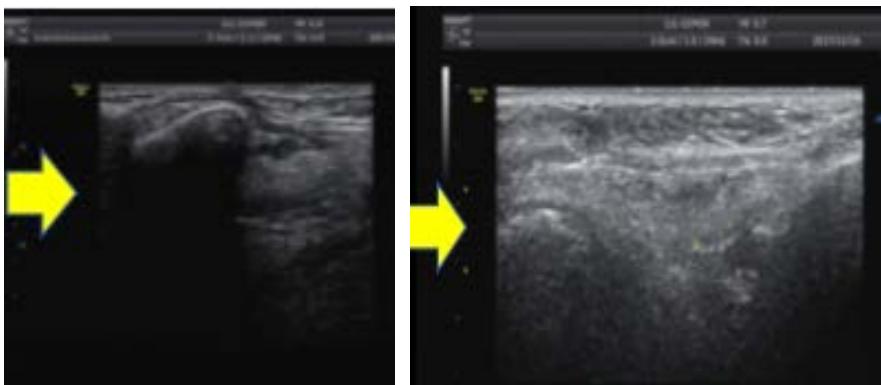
Ultrasound examination demonstrated that subcutaneous soft tissue thickness increased from 0.30 cm before implantation (left) to 1.35 cm 3 months after (right).
